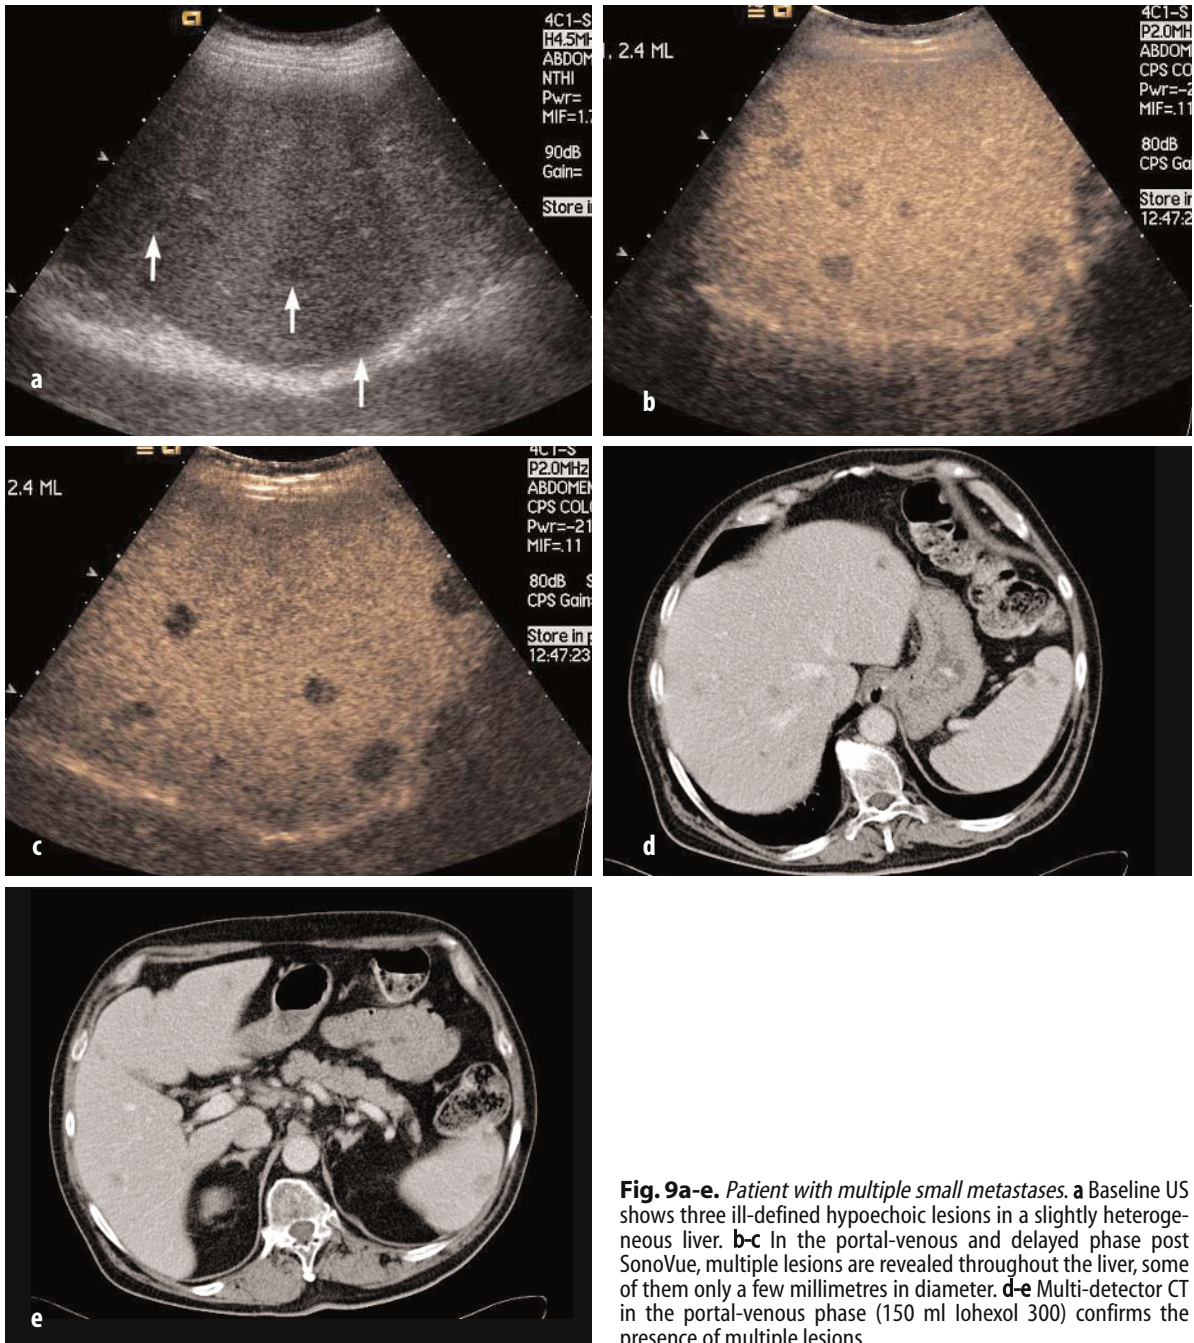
Patient with multiple small metastases. a Baseline US shows three ill-defined hypoechoic lesions in a slightly heterogeneous liver. b-c In the portal-venous and delayed phase post SonoVue, multiple lesions are revealed throughout the liver, some of them only a few millimetres in diameter. d-e Multi-detector CT in the portal-venous phase (150 ml Iohexol 300) confirms the presence of multiple lesions
